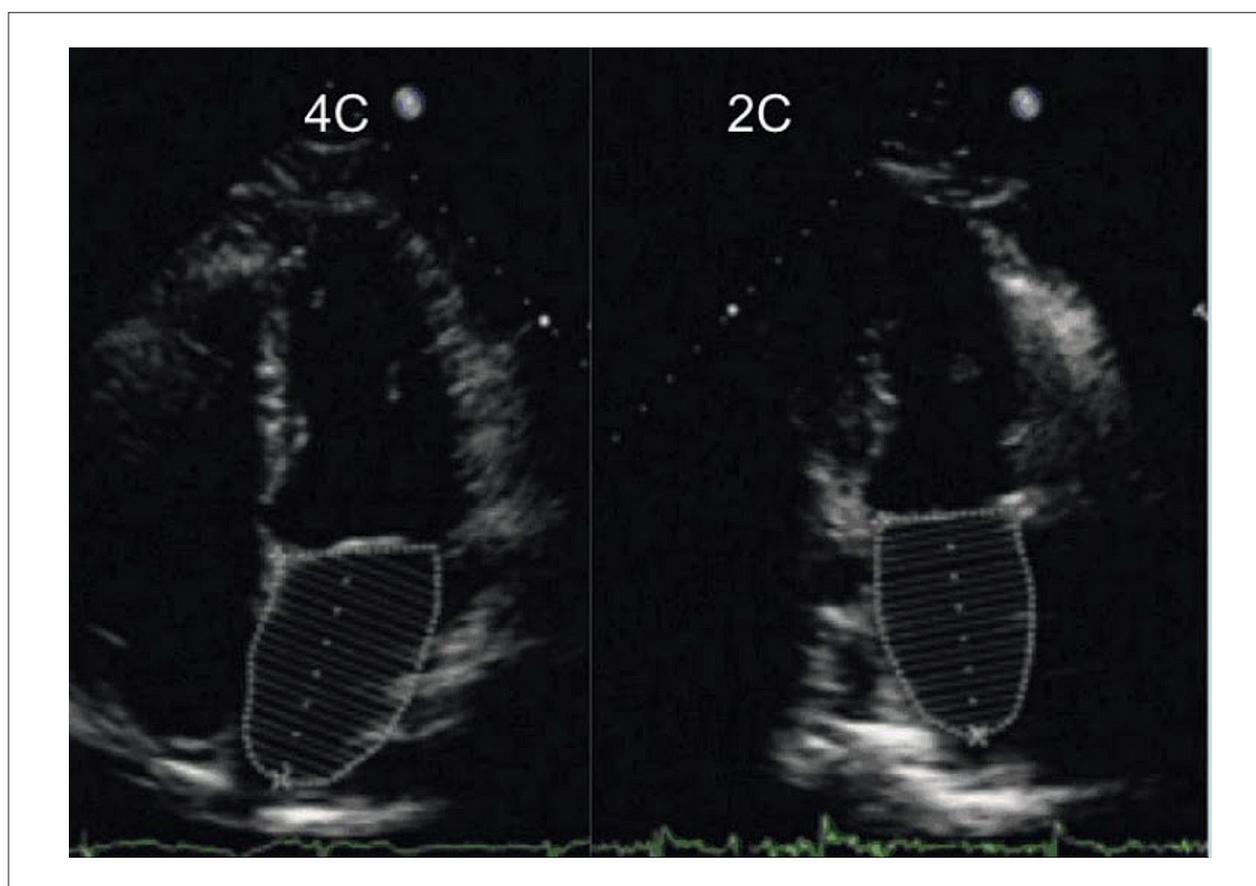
Apical 2- and 4-chamber views for left atrial volume calculation.
